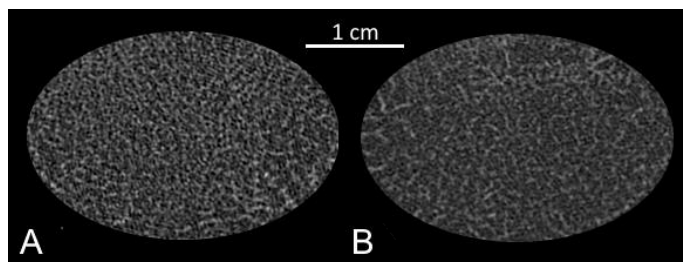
2D raw CT images of the ROI^T regions for human L3 vertebral bodies collected from 25-year-old subject (A) and 66-year-old subject (B).
